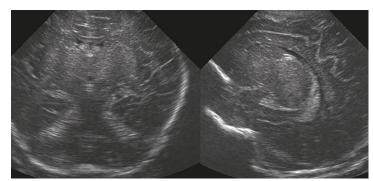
Term neonate in NICU with hipoxic ischemic encephalopathy and his brain ultrasound exam
